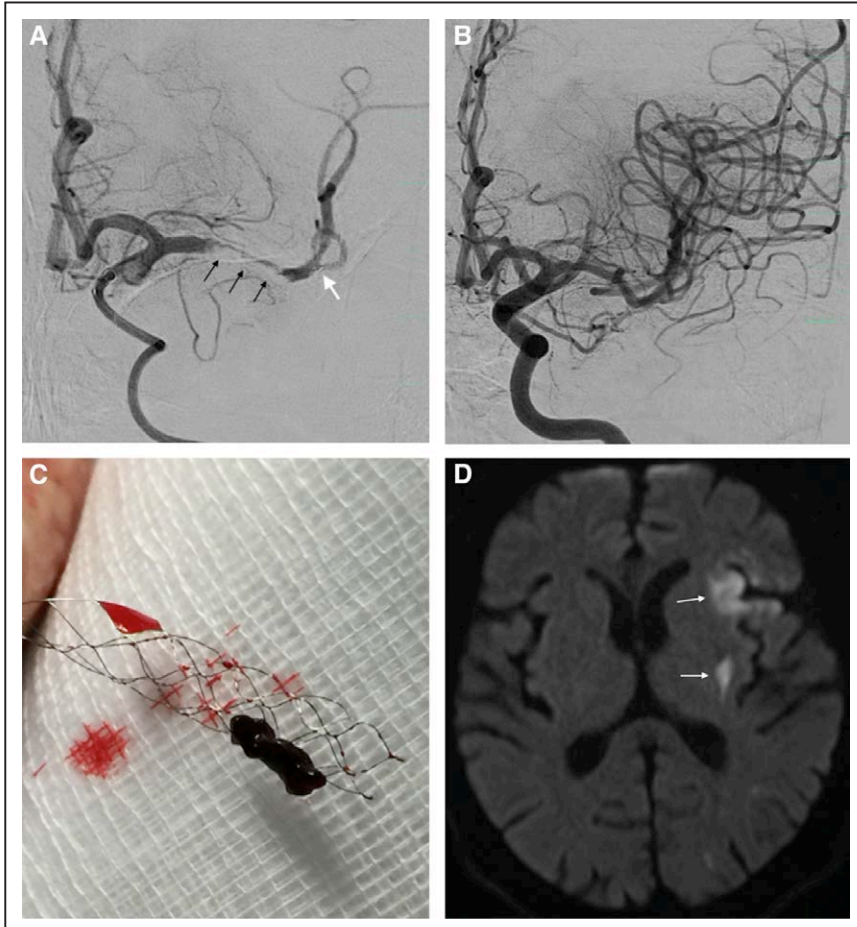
Endovascular thrombectomy with stent retriever in acute ischemic stroke. A, Acute middle cerebral artery occlusion and placement of stent retriever device with immediate flow restoration; distal end of the device (white arrow); the thrombus is pressed to the vessel wall (black arrows). B, Successful recanalization of the artery. C, Stent retriever with the extracted thrombus; (D) only a small infarction is seen in magnetic resonance imaging (white arrow).
